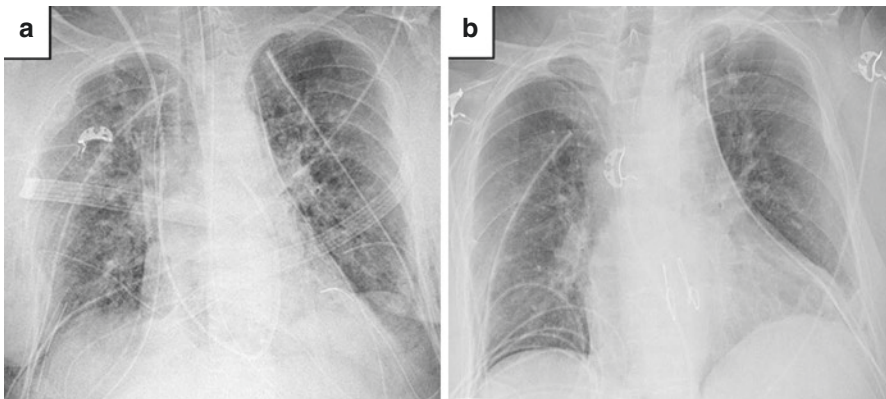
64 year old woman status post-double lung transplantation for idiopathic pulmonary fibrosis, complicated by initial severe vasoplegia requiring fluid and blood product resuscitation. On post-operative day 5 she developed increasing oxygen requirements while on mechanical ventilation, also in the setting of new onset atrial fibrillation. (a) Post-operative day 5 chest radiograph reveals diffuse airspace opacities suggestive of pulmonary edema. After aggressive diuresis and antiarrhythmic management of atrial fibrillation the patient improved, allowing for extubation and weaning from supplemental oxygen, with (b) chest radiograph on post-operative day 10 demonstrating improved opacities
